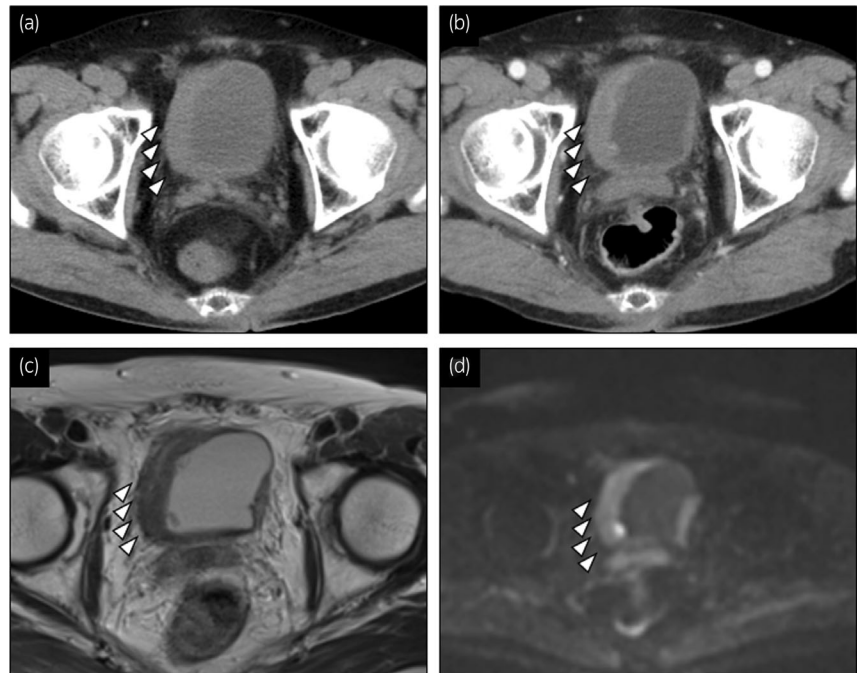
Abdominal CT showed a uniformly enhanced thickened right wall of the bladder with no suspected metastatic lesions (plain: a, enhanced: b). MRI revealed diffuse low intensity on T2-weighted images and uniform high intensity with focal strong intensity on diffusion-weighted images; these suggested advanced-T stage bladder cancer (T2: c, diffusion: d). (white arrowheads).
